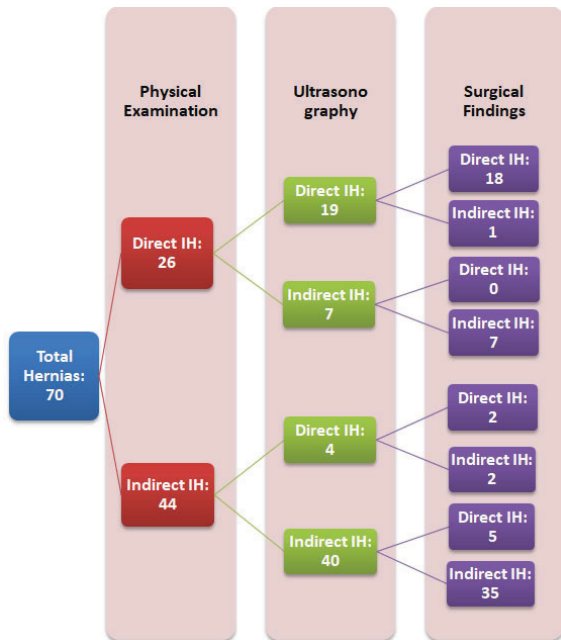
Combined Physical examination and Ultrasonography results of type of inguinal hernia
